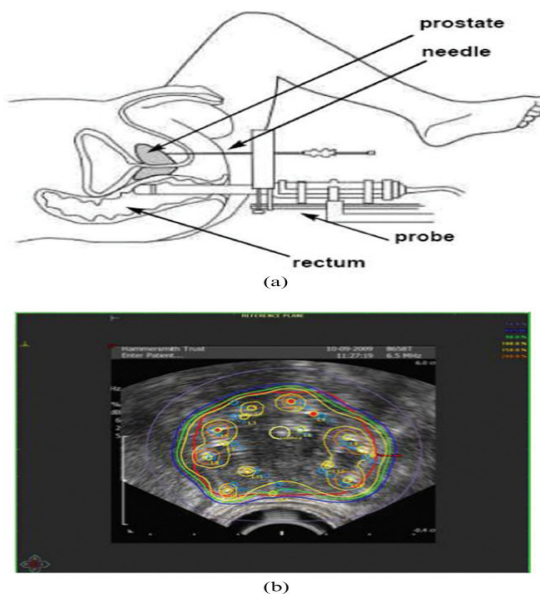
Figure - (a) Needle insertion is carried out via transperineal implantation under ultrasound guidance.
